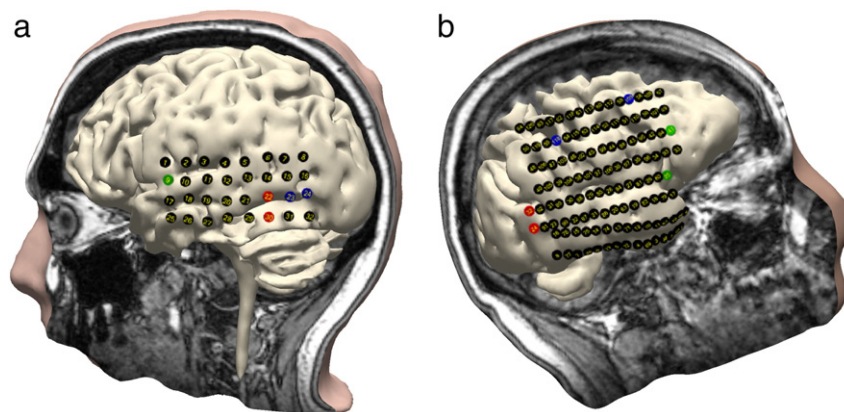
Structural MRI co-registered with CT scan to show grid electrode implantation locations. For both patients the electrodes over the epileptic focus are plotted in red, the channels used for the probing stimulus are plotted in blue, and the channels used as a reference are plotted in green. (a) Patient 1 with a 32-channel grid electrode. (b) Patient 2 with a 120-channel grid electrode.
